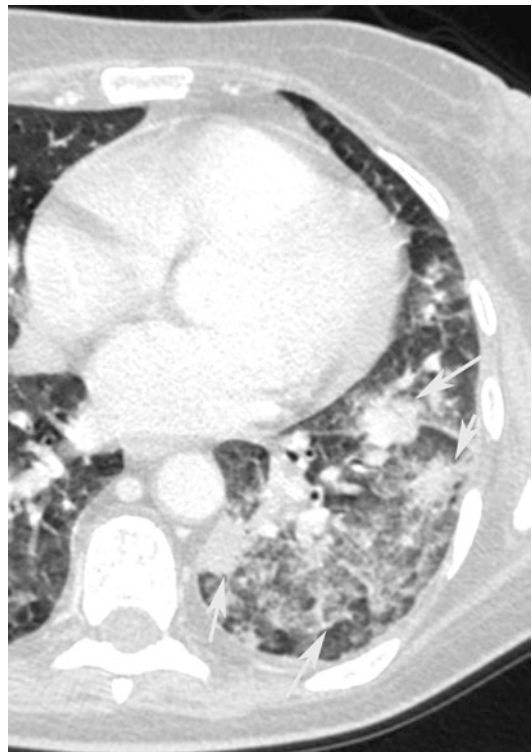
Bronchopneumonia. CT axial scan demonstrates multiple, lobular (arrow), patchy, confluent consolidation areas of the left lower lobe
